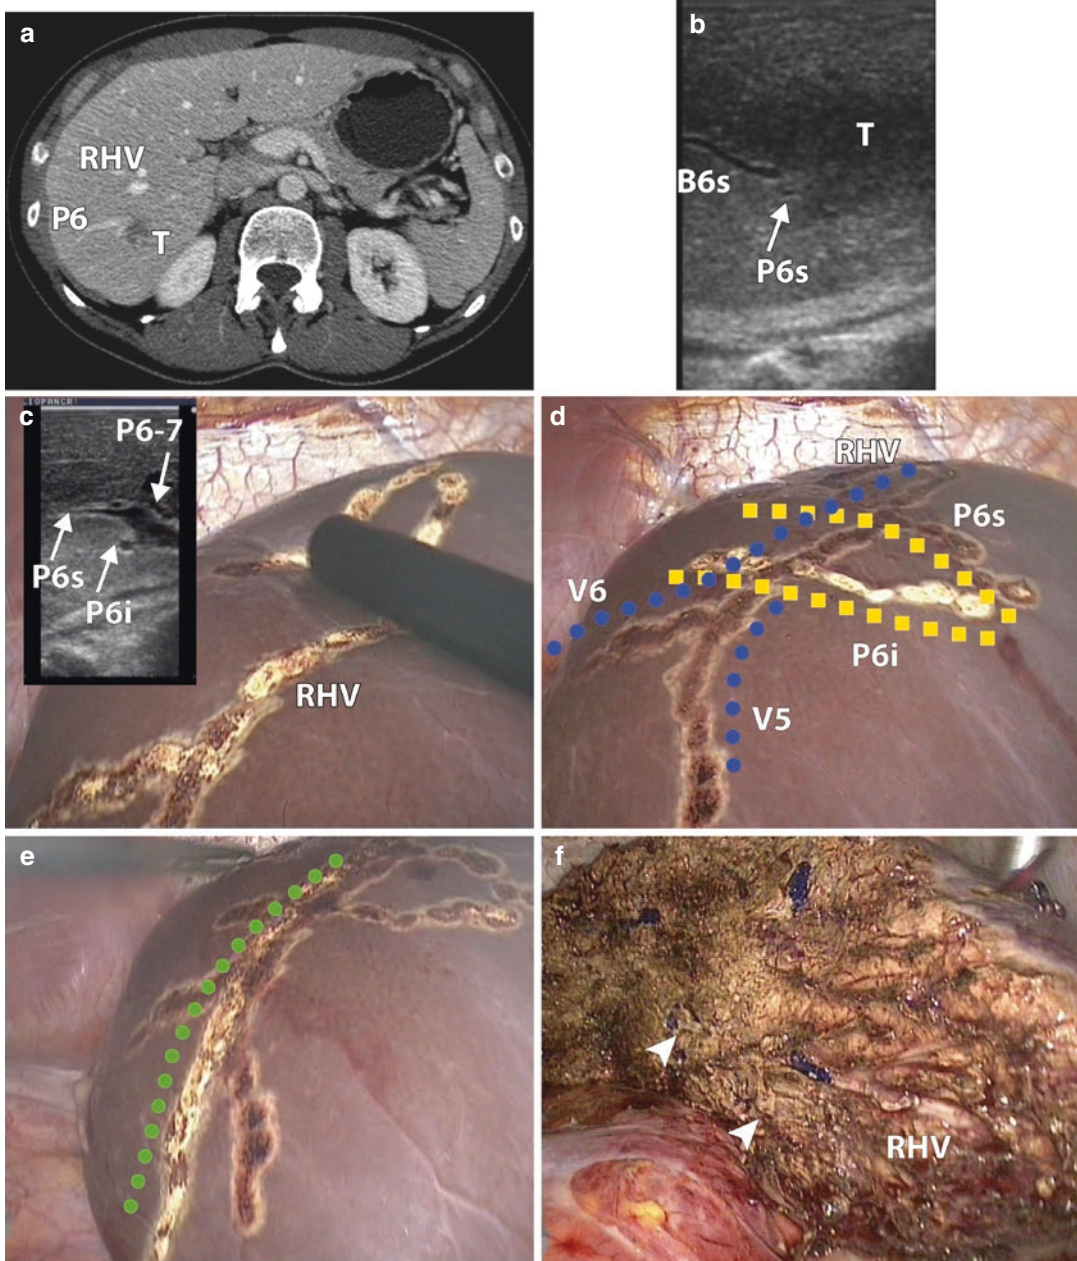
Laparoscopic ultrasound (LUS) guidance to resection. (a) CT scan of a colorectal liver metastases (*T*) in Sg6, in contact with a Sg6 portal branch (*P6*). *RHV*; right hepatic vein. (b) LUS showing an hypoechoic metastasis in contact with Sg6 superior pedicle (*P6s*) with dilatation of the corresponding bile duct (*B6s*). (c) LUS identification of Sg6 superior (*P6s*) and inferior (*P6i*) pedicles at the origin from the posterior portal branch (*P6-7*). *RHV* has already been marked on liver surface. (d) All the landmarks required for a Sg6 resection are marked on liver surface. *RHV* (blue dotted line) with a branch
